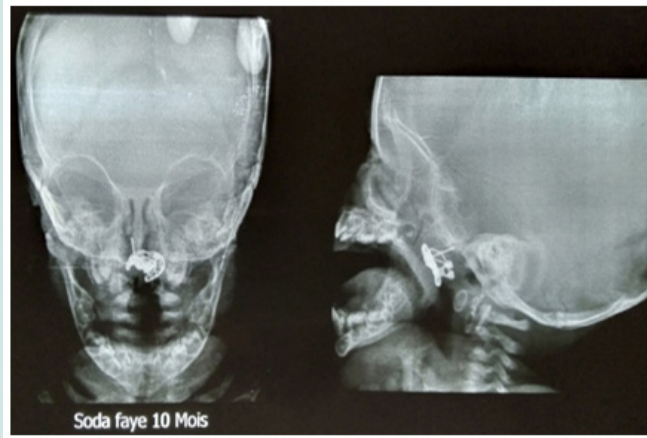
Frontal and lateral X-ray: anteroposterior view showing foreign body at the level of the nasopharynx.
